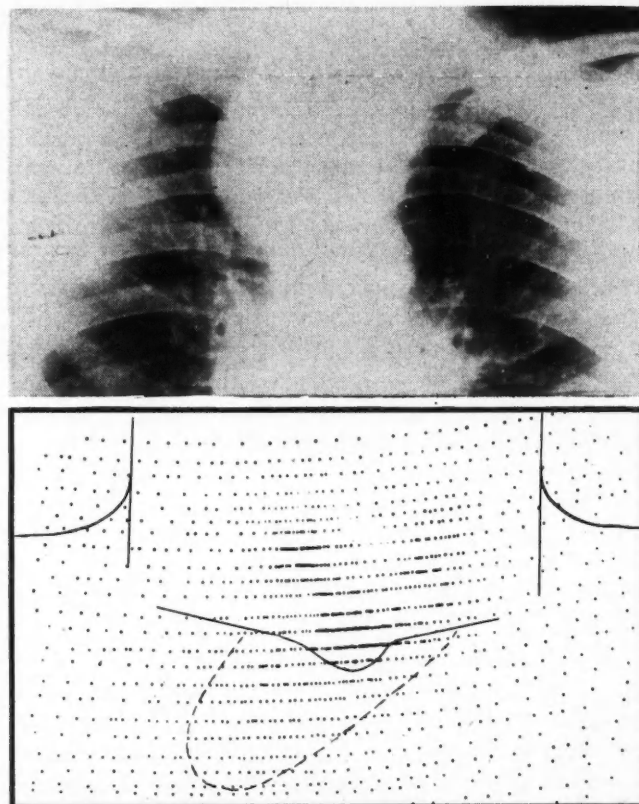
Chest radiograph showing presence of superior mediastinal mass, and scan showing that this mass was associated with cervical thyroid, was avid for  $I^{131}$  and, therefore, was a mediastinal goitre.
